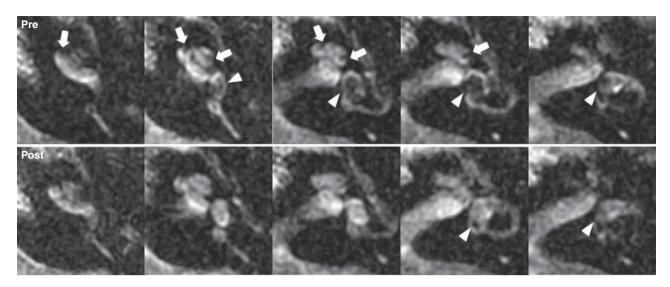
An example of reduced endolymphatic hydrops (case P43). Upper panels are images taken before, and lower panels 6 months after, sac surgery. From the left to the right, caudal to rostral axial views of the inner ear are depicted by Gd-contrasted perilymphatic space. Gd contrast medium was applied intravenously for both examinations. Arrows indicate low signal intensity areas corresponding to the cochlear duct, apparently indicating cochlear hydrops. As for the vestibule, low intensity areas indicated by arrowheads occupy more than 33.3% of the vestibule, indicating vestibular hydrops in the preoperative MRI. The postoperative MRI did not show either cochlear or vestibular hydrops.
